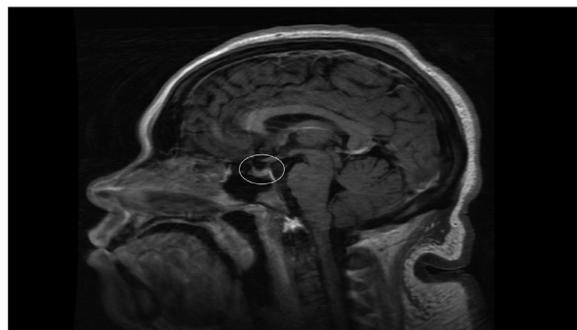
Sagittal T1 Fluid Attenuated Inversion Recovery (FLAIR) MRI of the brain showing a partially empty sella (encircled).
